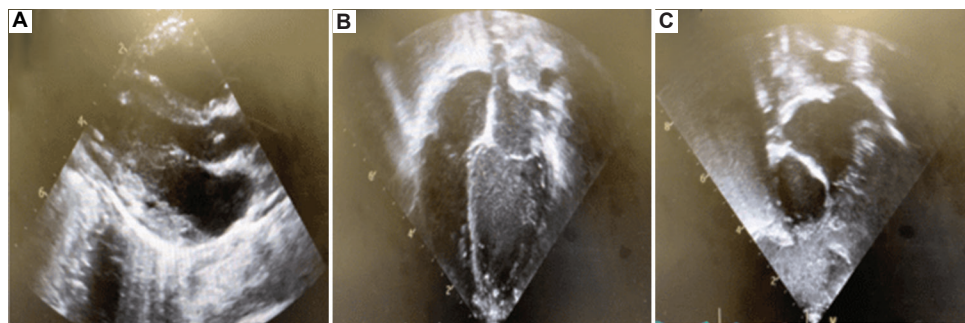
Post-operative echocardiogram demonstrates successful surgical management without evidence of thrombi. (A) Parasternal long-axis view; (B) apical four-chamber view; and (C) subcostal view.
